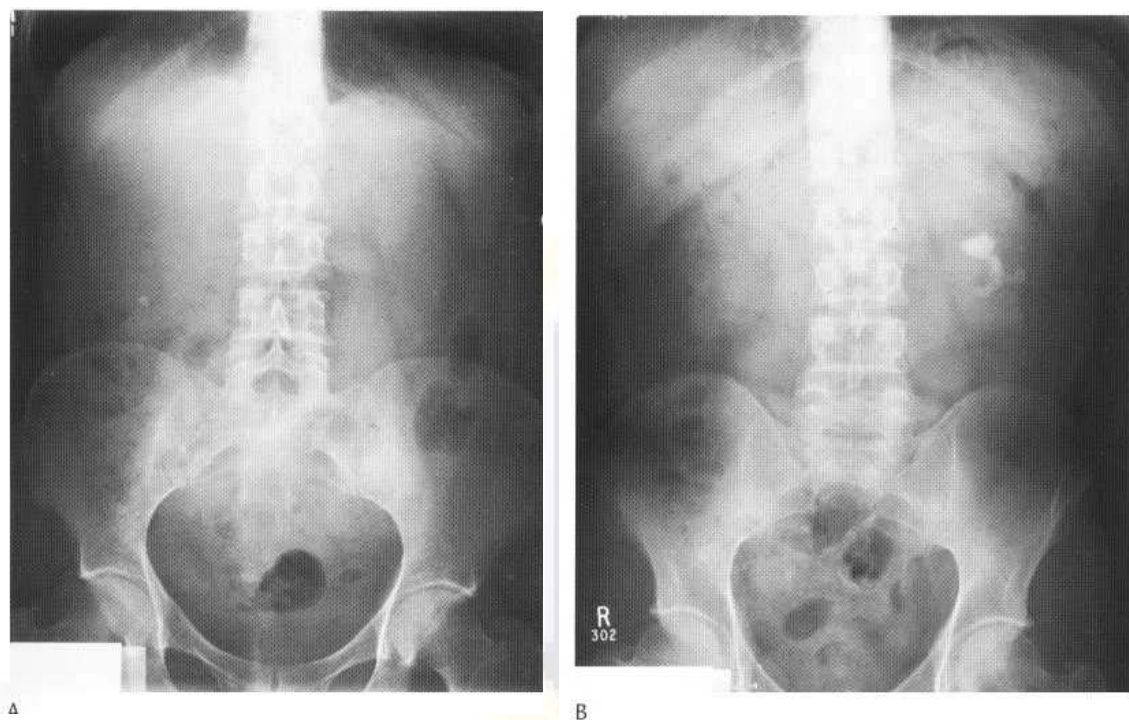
(A) Small right renal calculus visible on plain film and larger calculus (B) in the left lower pole major calyx.
